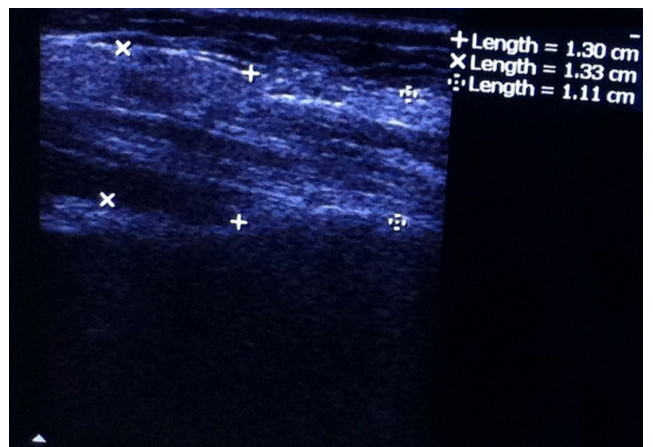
Ultrasonographic image of the masseter muscle in chronic chewer – contracted state
